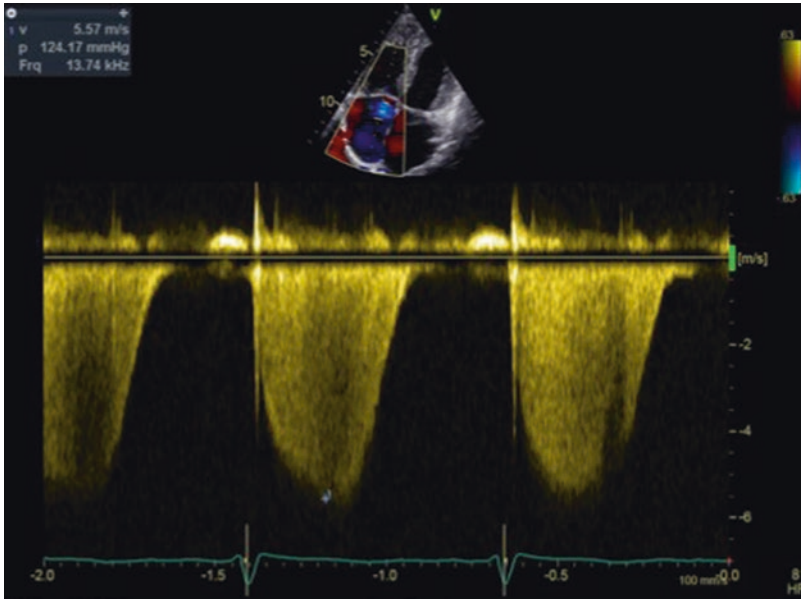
Transthoracic echocardiography, apical 4-chambers view, continuous-wave Doppler examination at the level of tricuspid valve: a peak tricuspid regurgitation velocity of 5.57 m/s is measured, allowing an estimation of systolic PAP of 129 mmHg
